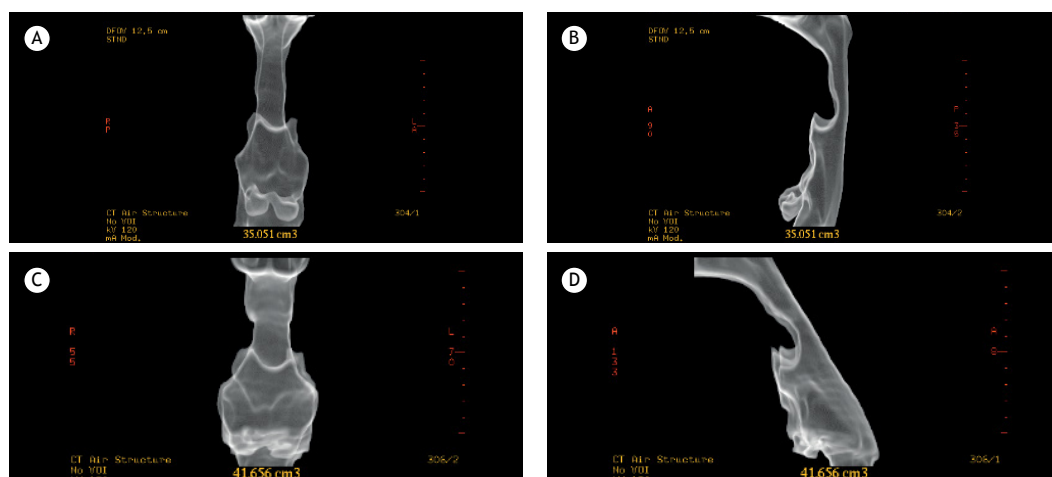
Cervical CT for determining upper airway volume—in the neutral position (without head elevation): anterior view (in A) and lateral view (in B); and with the head elevated by 44° with a wedge: anterior view (in C) and lateral view (in D). Volume was measured from the hard palate to the base of the epiglottis.
